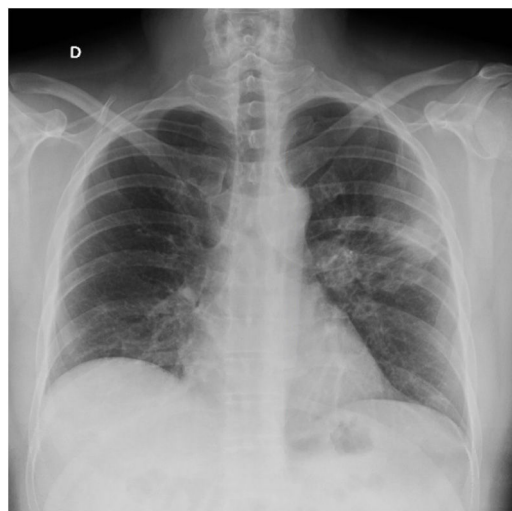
Chest radiography showing right lower lobe opacification and left lingula consolidation.
